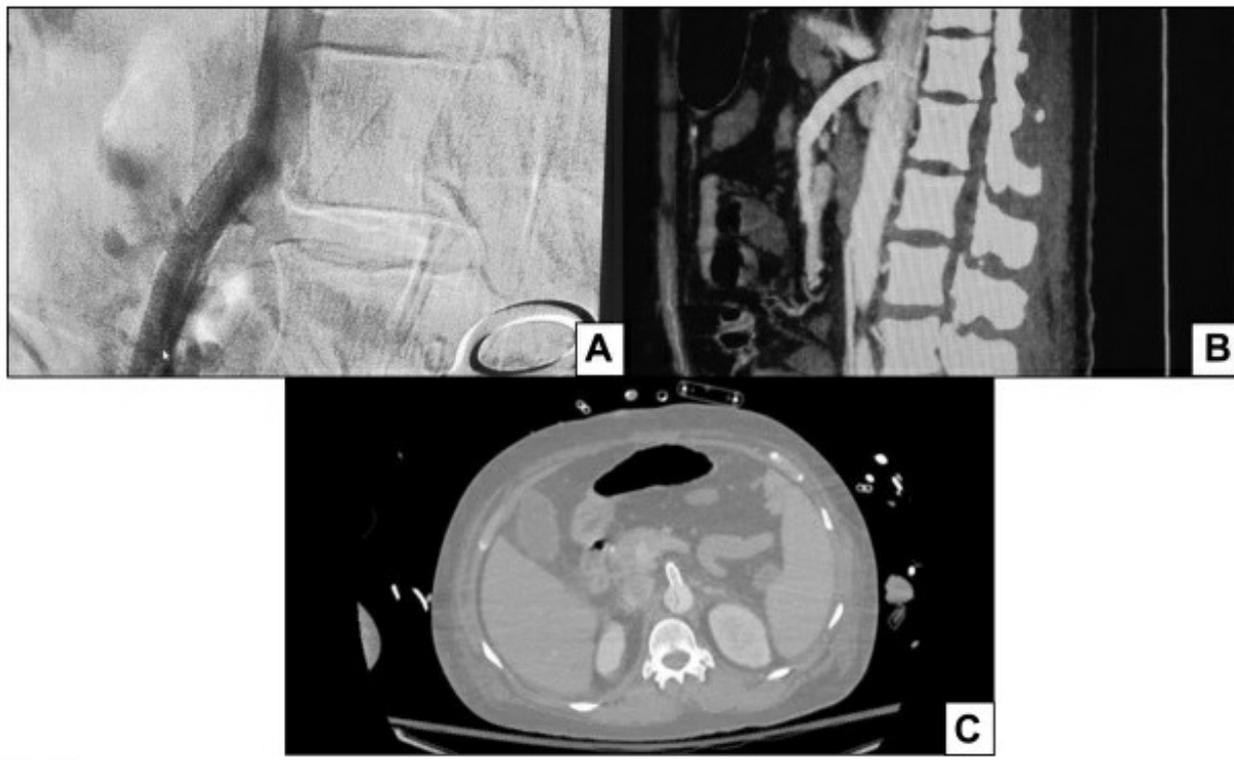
Imaging of intraoperative and postoperative findings for revascularization of the superior mesenteric artery (SMA) by retrograde stenting. A, Intraoperative angiogram. B, Postoperative computed tomography angiography (CTA) image. C, True lumen expansion after hemiarch replacement.
